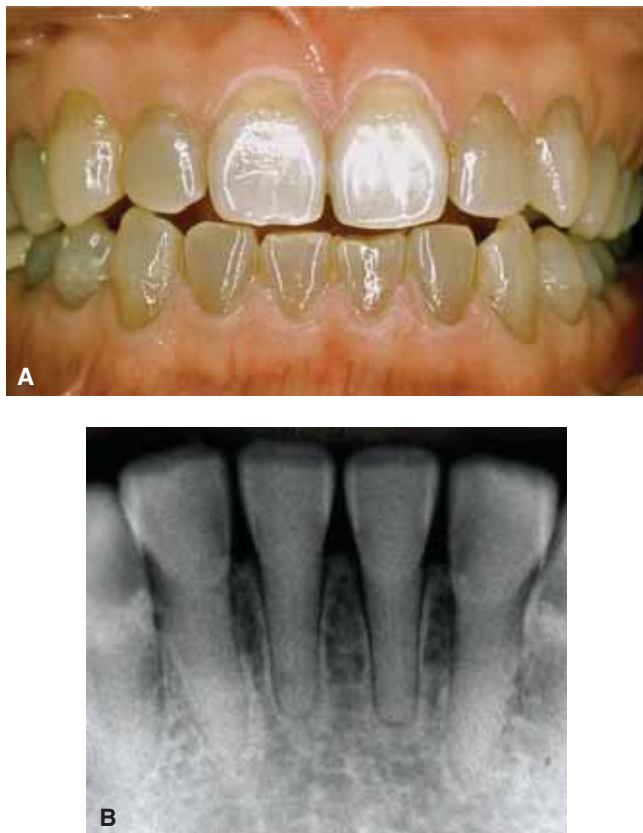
Dentinogenesis imperfecta (opalescent dentin) is a hereditary disorder that affects the dentin and external appearance of all teeth. This condition occurs only once in every 8000 people. A. The teeth take on a gray or yellow opalescent appearance. B. Radiographs reveal the total or partial lack of pulp chambers and canals. (Courtesy of Carl Allen, D.D.S., M.S.D.)
